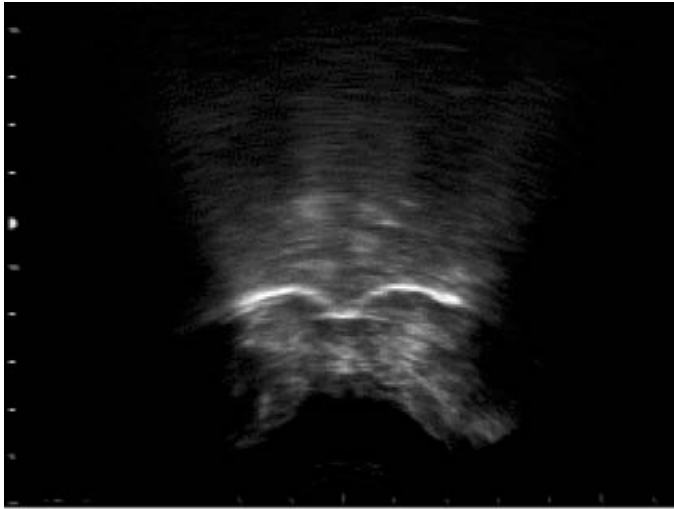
A coronal ultrasound display of a typical adult /s/ showing a mid-line tongue groove and raised lateral margins of the tongue.
